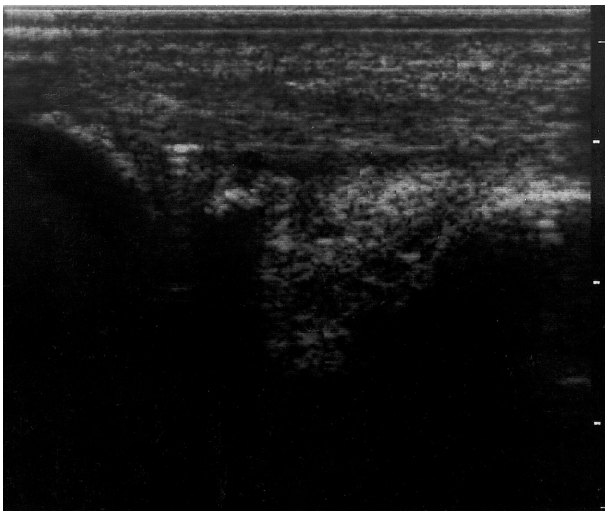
Ultrasonography of the left knee performed 4 months after the operation showing good healing of the avulsed patellar tendon.
